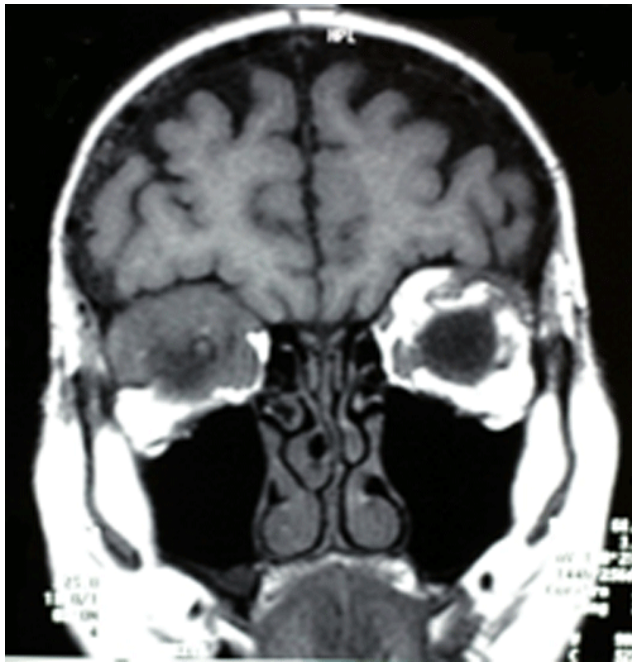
Axial T1 MRI of skull showing an abnormal infiltrating lesion at the right orbital apex involving all four rectus muscles
